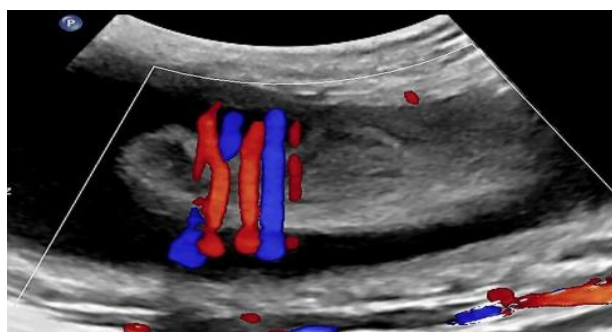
Longitudinal (sagittal) colour doppler view of neck.
